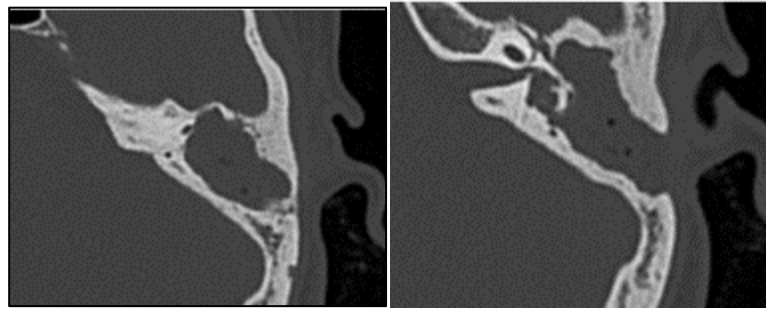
CT axial (b) and coronal (a) images of tegmen tympani and sigmoid sinus erosion
